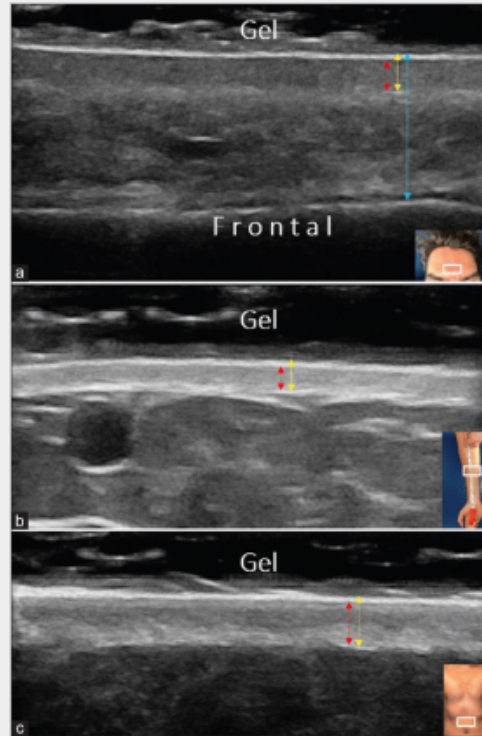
Short-axis ultrasonographic thickness measurements from the forehead (just above the glabella) (a), forearm at the midpoint between the antecubital fossa and the wrist (b), and the umbilicus (just above the navel) (c). Red arrow: Dermis thickness, Yellow arrow: Skin (epidermis and dermis) thickness, Blue arrow: Soft-tissue thickness (from the upper layer of the epidermis to the frontal bone). Note that insets show the probe position with a blanked box. Note that the red arrow represents only the upper dermis in the forehead. Note that the lower dermis is identified as the hyperechoic layer located just below the upper dermis in the forehead
